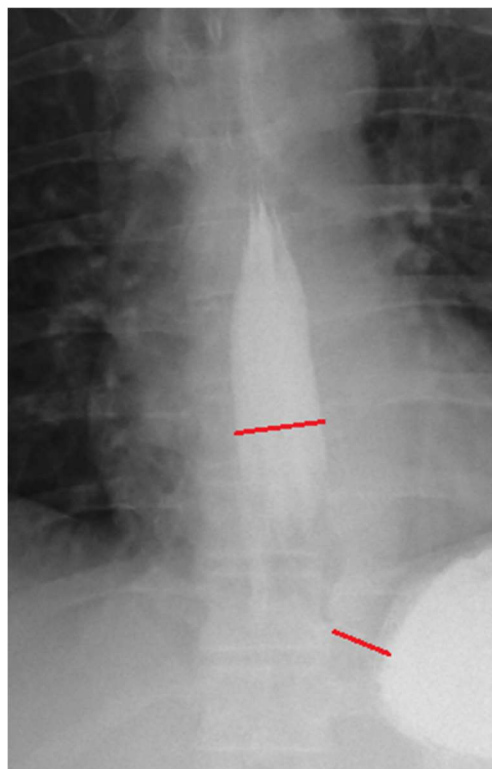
A strong peristaltic wave is detected on the x-ray. The esophagus is dilated with the presence of longitudinal folds. Its maximum width is 2.6 cm. The length of the LES is 2.2 cm. The severity of reflux, defined, as the ratio of the width of the esophagus to the length of the LES (X-ray index reflux –XIR), is 1.2. This is the smallest indicator among family members who have had a similar study. Conclusion: Mild GERD.
